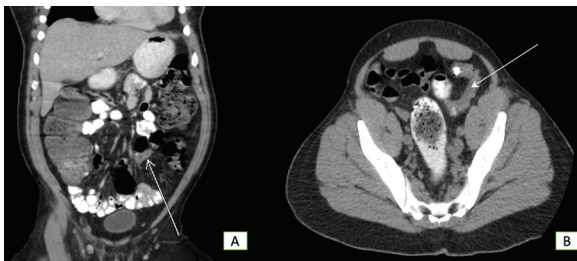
Coronal view in first CT scan showing focal region of thickening which measured approximately 2 cm concerning for possible sigmoid stricture Figure 1B. Transverse view in repeat CT scan showing a 4-6 cm segment of decompressed mid sigmoid colon with proximal large fecal burden and distension
